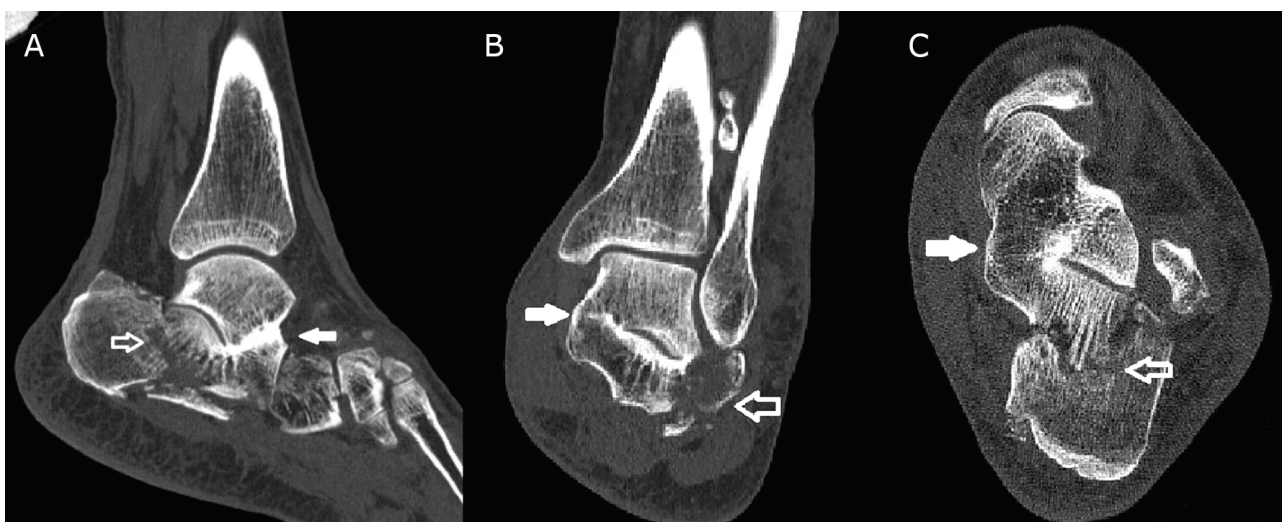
The sagittal (A), coronal (B) and axial (C) ankle CT scans showing the calcaneal fracture (white arrow) and the coalition of the middle facet (filled white arrow) of the subtalar joint.
